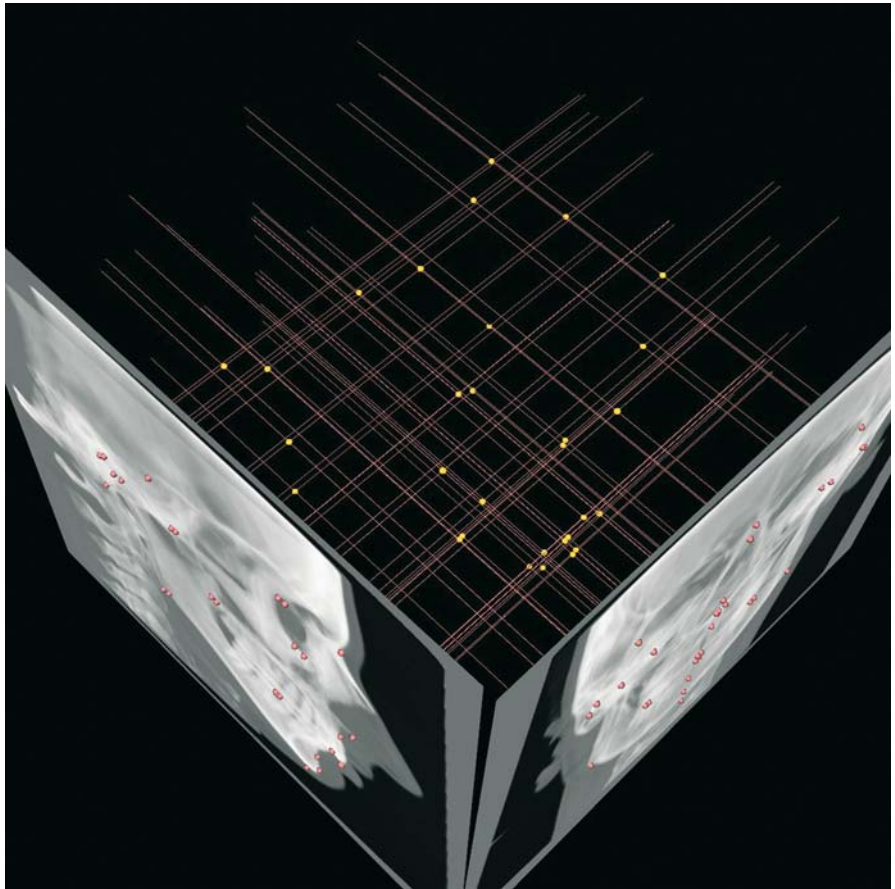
Set-up of 3-D cephalometric hard tissue landmarks. Virtual frontal cephalogram (3-D CT, patient K.C.)
